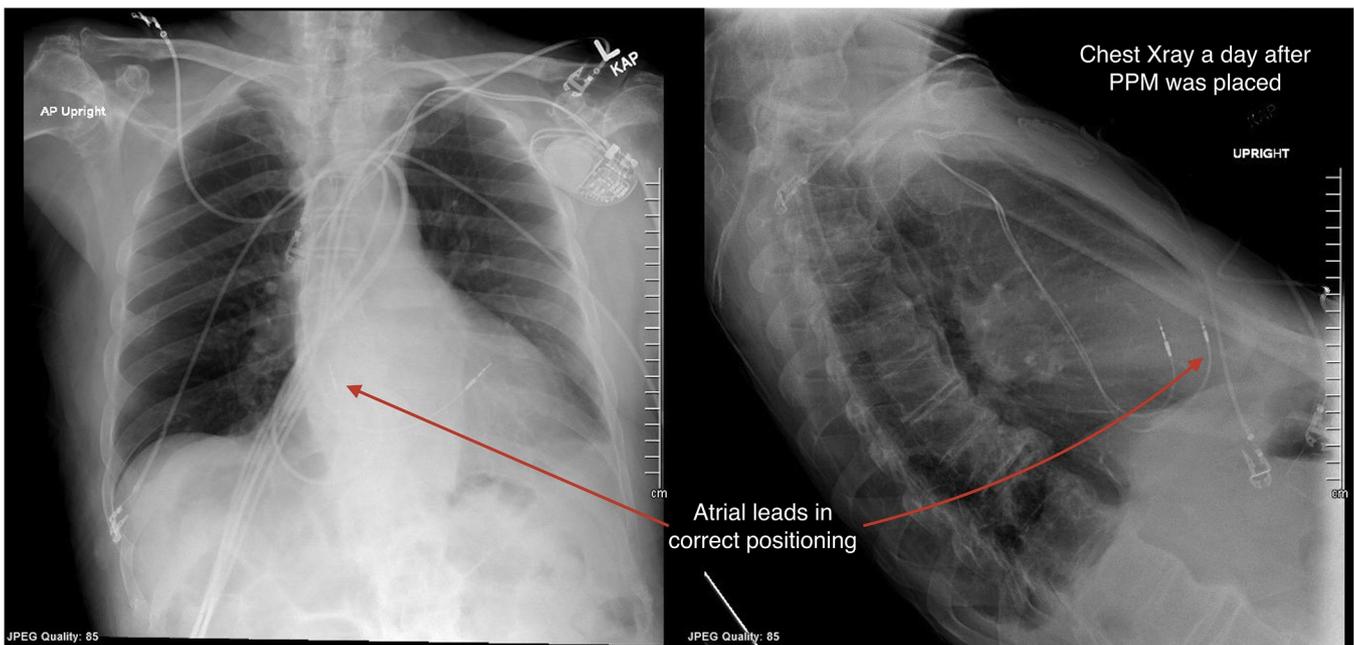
Chest X-ray 2 views, one day after placement of the pacemaker 4 months ago showing correct positioning of the atrial and ventricular leads.
